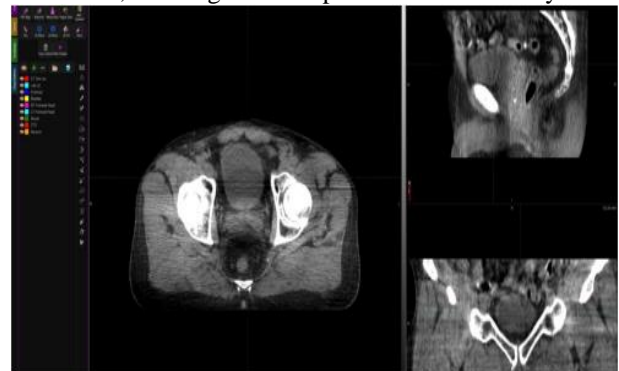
Daily CT for contouring in MIM
